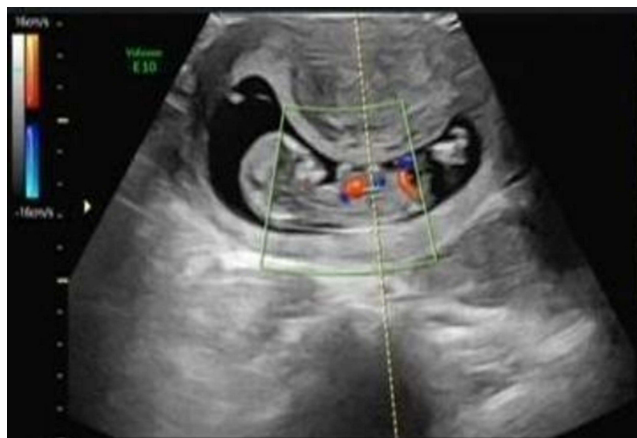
Ultrasonography image of the uterus showing an intrauterine gestation.
